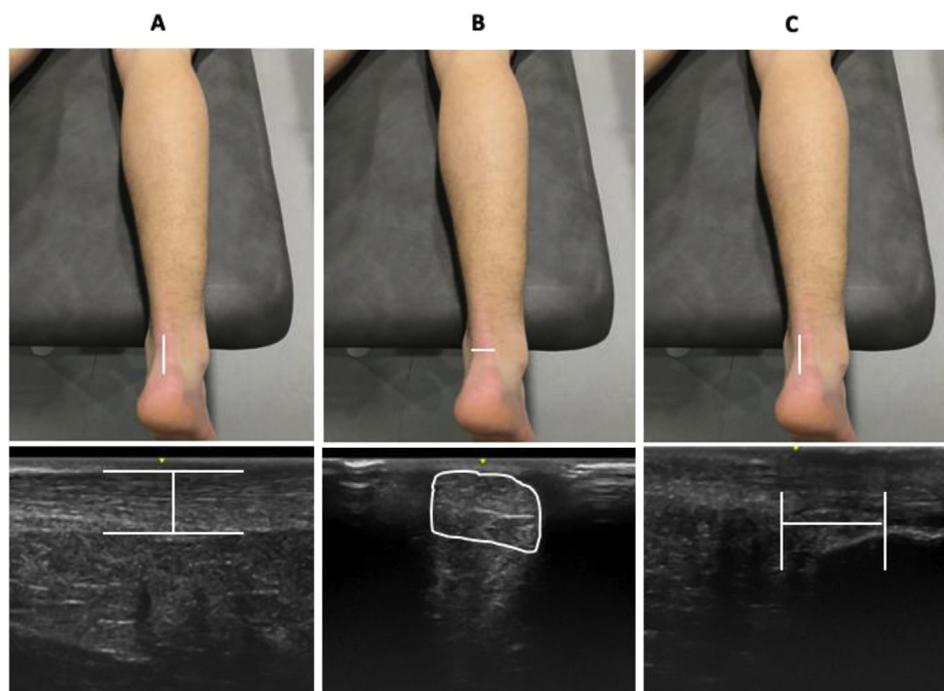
Transducer places during ultrasound evaluation of the thickness, cross-sectional area and Kager's fat pad.
